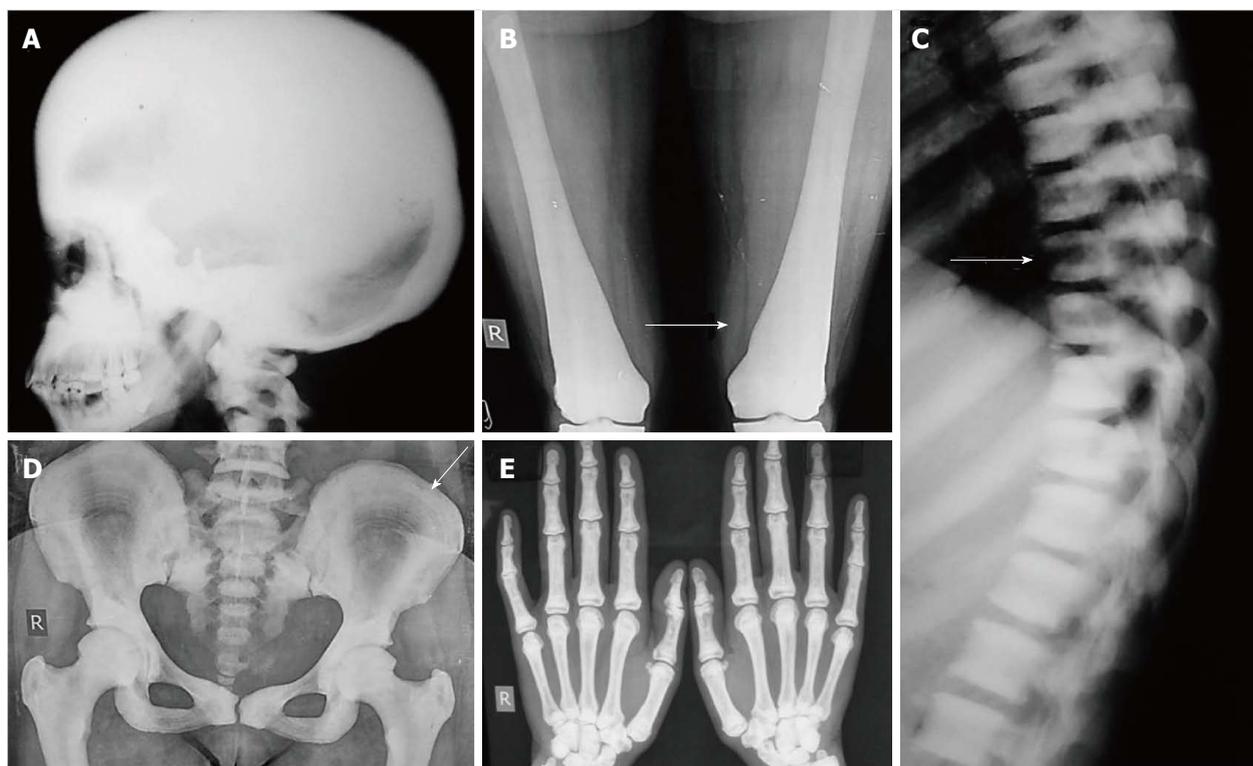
Osteopetrosis. Radiograph of skull shows diffusely increased density (A). Radiograph of bilateral femurs show obliteration of medullary cavity and Erlenmeyer flask deformity (arrow, B). Also note sandwich vertebrae (arrow, C) bone-within-bone appearance in pelvis (arrow, D) and increased density in hand bones (E).
